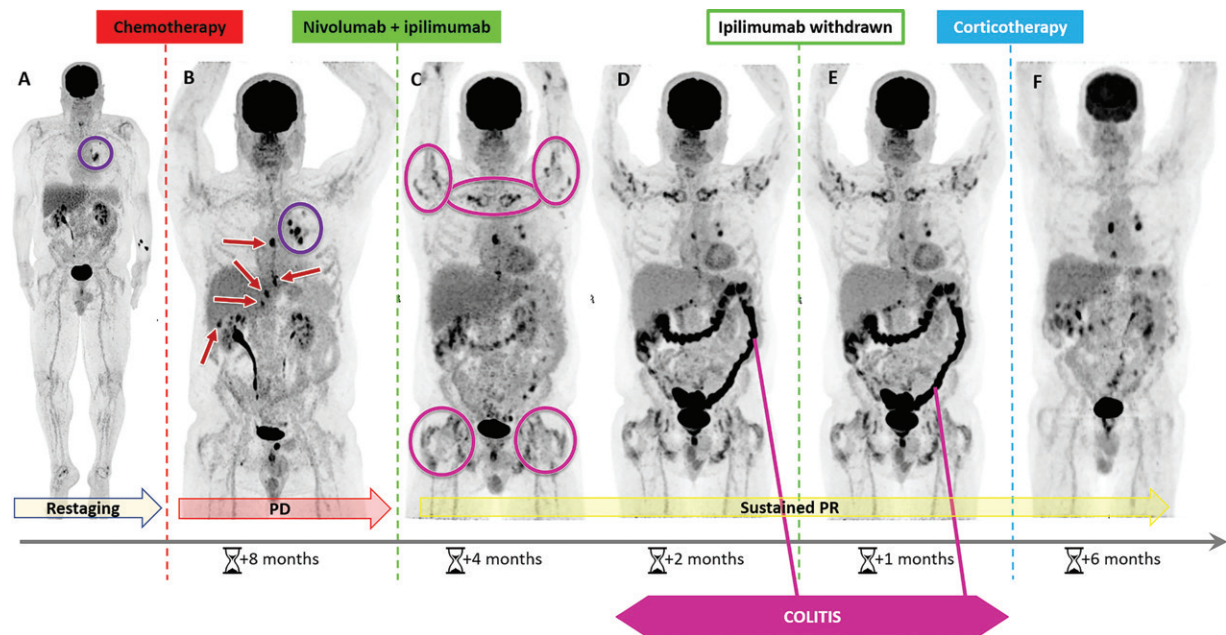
Immunotherapy-induced colitis, arthritis, and synovitis in a 67-year-old man with metastatic non-small cell lung cancer. *A*, MIP FDG PET image shows the appearance at restaging. Purple circle = active mediastinal nodal disease. *B*, Image after chemotherapy shows progressive disease (PD). Purple oval = active mediastinal nodal disease, arrows = PD sites after chemotherapy: thoracic and abdominal nodes. *C*, *D*, Images after nivolumab and ipilimumab therapy show a sustained partial response (PR), with the appearance of multiple sites of arthritis and synovitis (pink ovals) and mild and diffuse bowel hypermetabolism. *E*, Image after withdrawal of ipilimumab therapy shows that the findings have not resolved. *F*, Image shows that the findings responded to steroid therapy.
